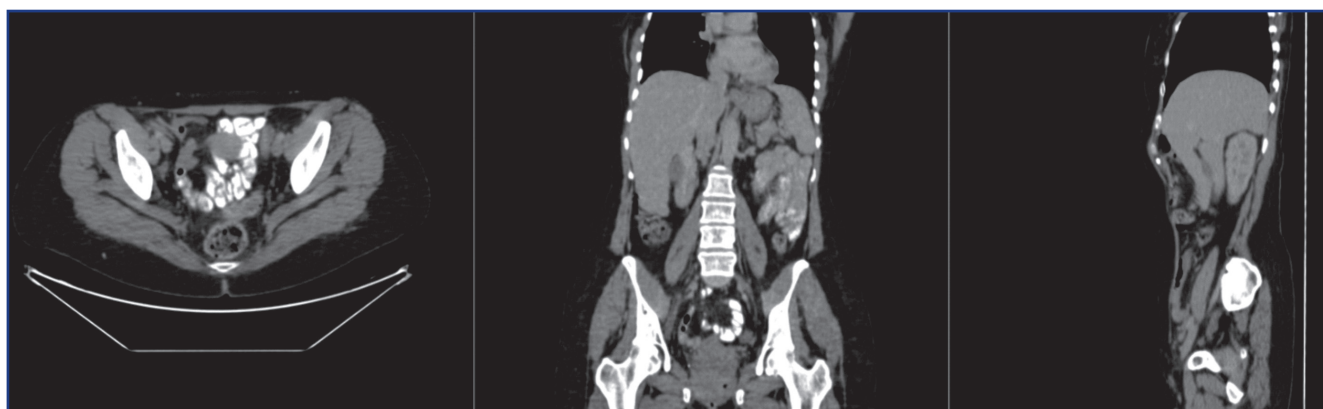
CT of the chest, abdomen and pelvis with intravenous contrast on January 03, 2023
